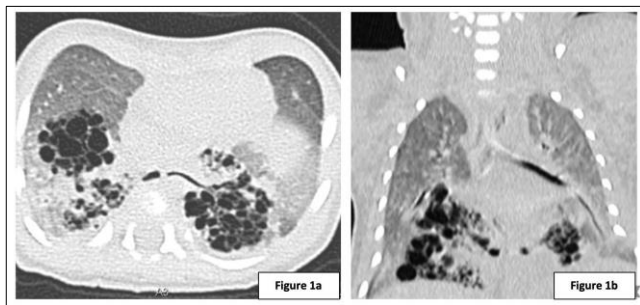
(a & b): CT scan (axial and coronal section) showing an isthmus connecting the right and left lower lobe with multicystic lesions and surrounding ground glass pattern. The findings depict bilateral lower lobe congenital pulmonary airway malformations with horseshoe lung.
